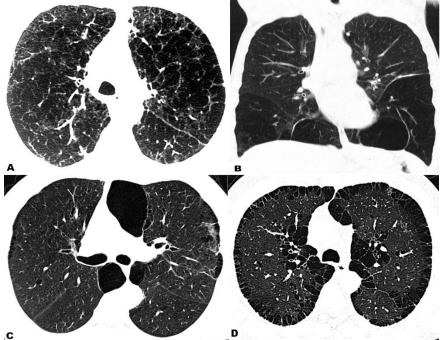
COPD HRCT aspect (MDCT): axial and coronary sections, with anatomical distribution of emphysema: A: centrolobular emphysema, B: panlobular emphysema, C: bulos emphysema, D: paraseptal emphysema
